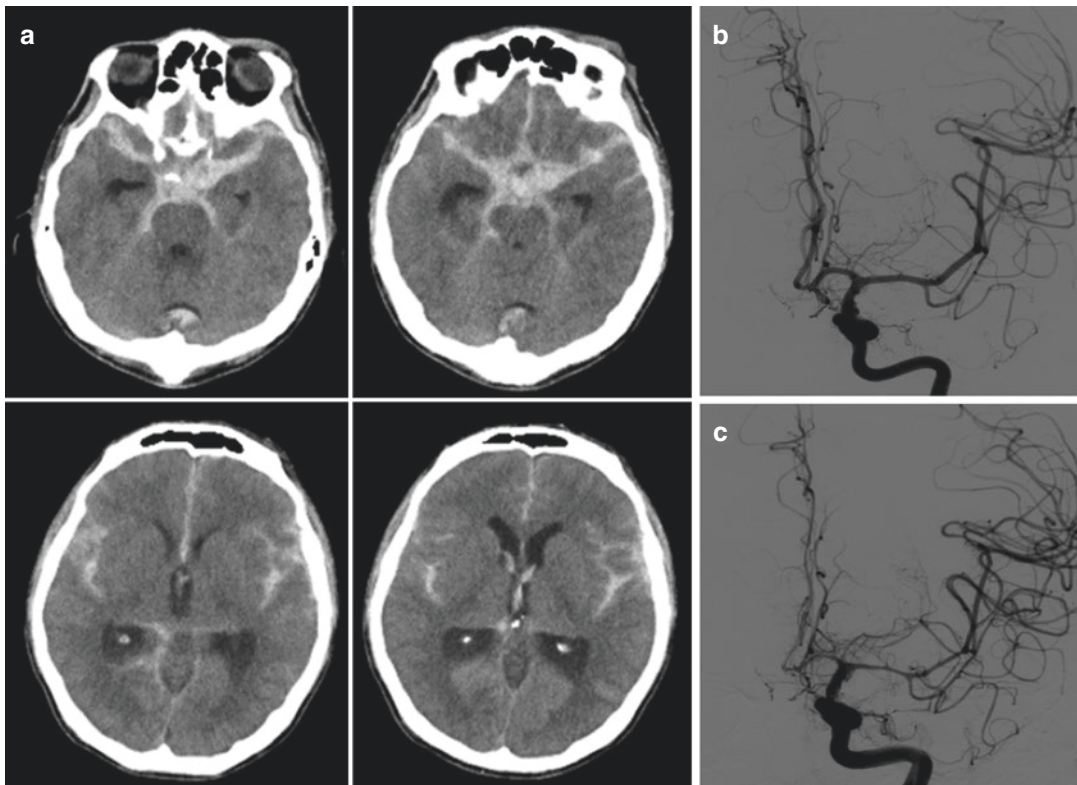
(a) A 45-year-old male presents with sudden severe headache. Computed tomography (CT) scan shows acute subarachnoid hemorrhage. (b) Subsequent angiography reveals cerebral aneurysm arising at the left posterior communicating artery. The aneurysm was secured by
